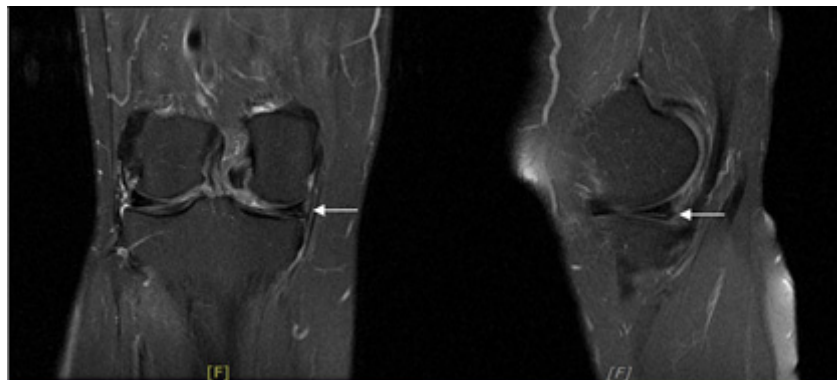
Right knee MRI from case 1(11/28/2019).
